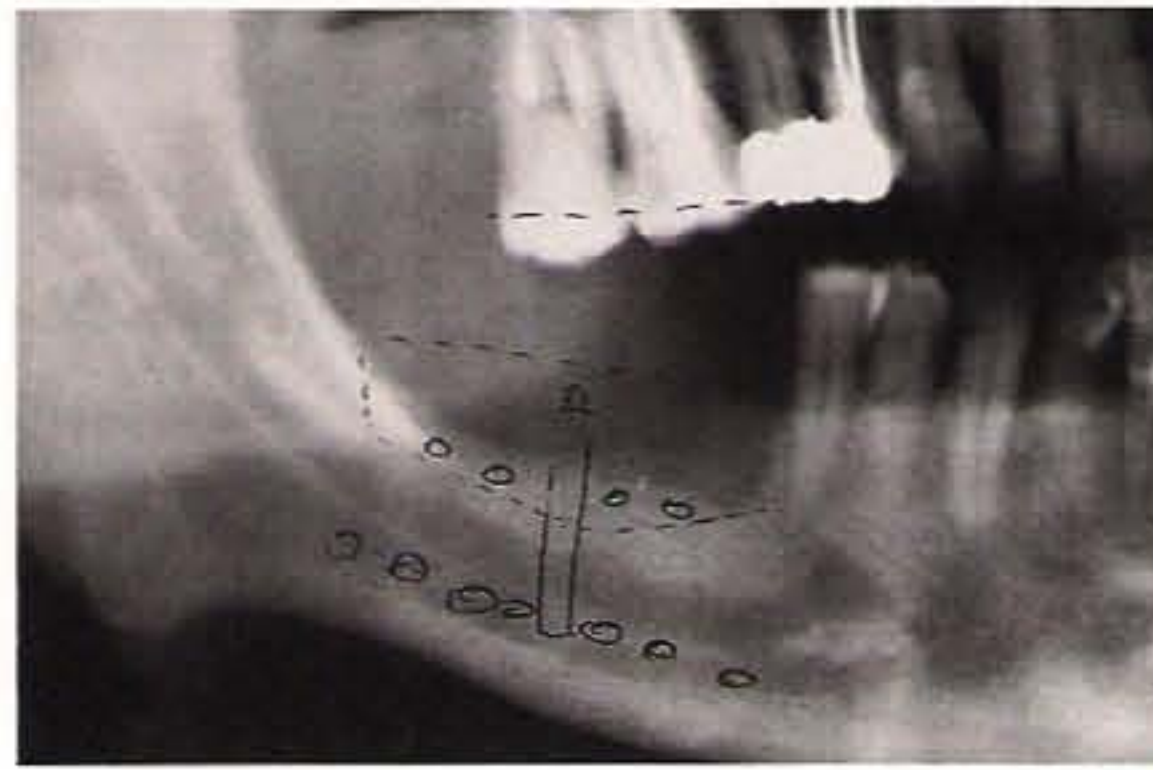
The initial panoramic radiograph shows the lack of bone in the edentulous crest.
